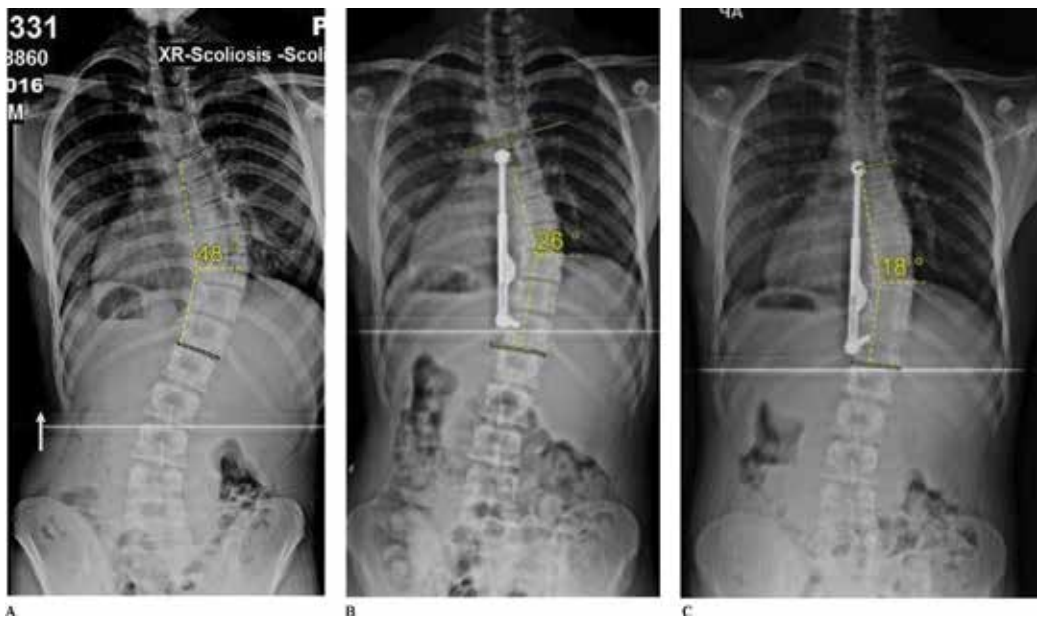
Case 1: (A) Preoperative standing AP X-ray, (B) postoperative standing AP X-ray, and (C) after 3 months of exercises. The expandable rod has elongated with further curve reduction.
